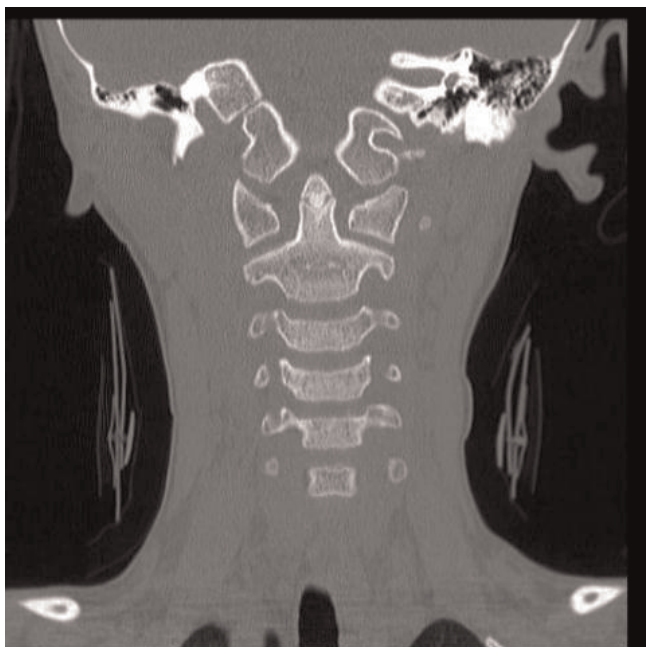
Coronal reconstructed CT of the odontoid complex demonstrates clear and intact cortical margins of the apical ossicle separate from the odontoid proper. There is no radiographic evidence of fusion.
